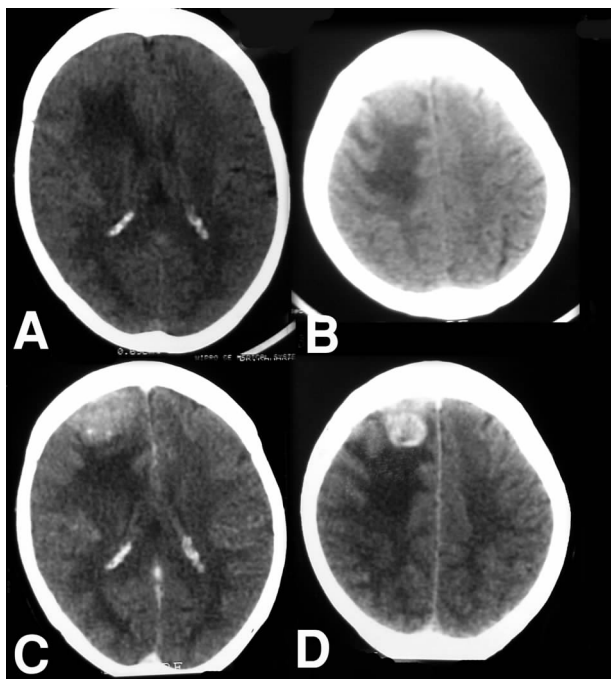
Plain CT scan (A and B) showing an isodense lesion enhancing after contrast administration (C and D) with an enhancing ring and a small central lucent area (D), note the associated perileiosnal oedema and mass effect
